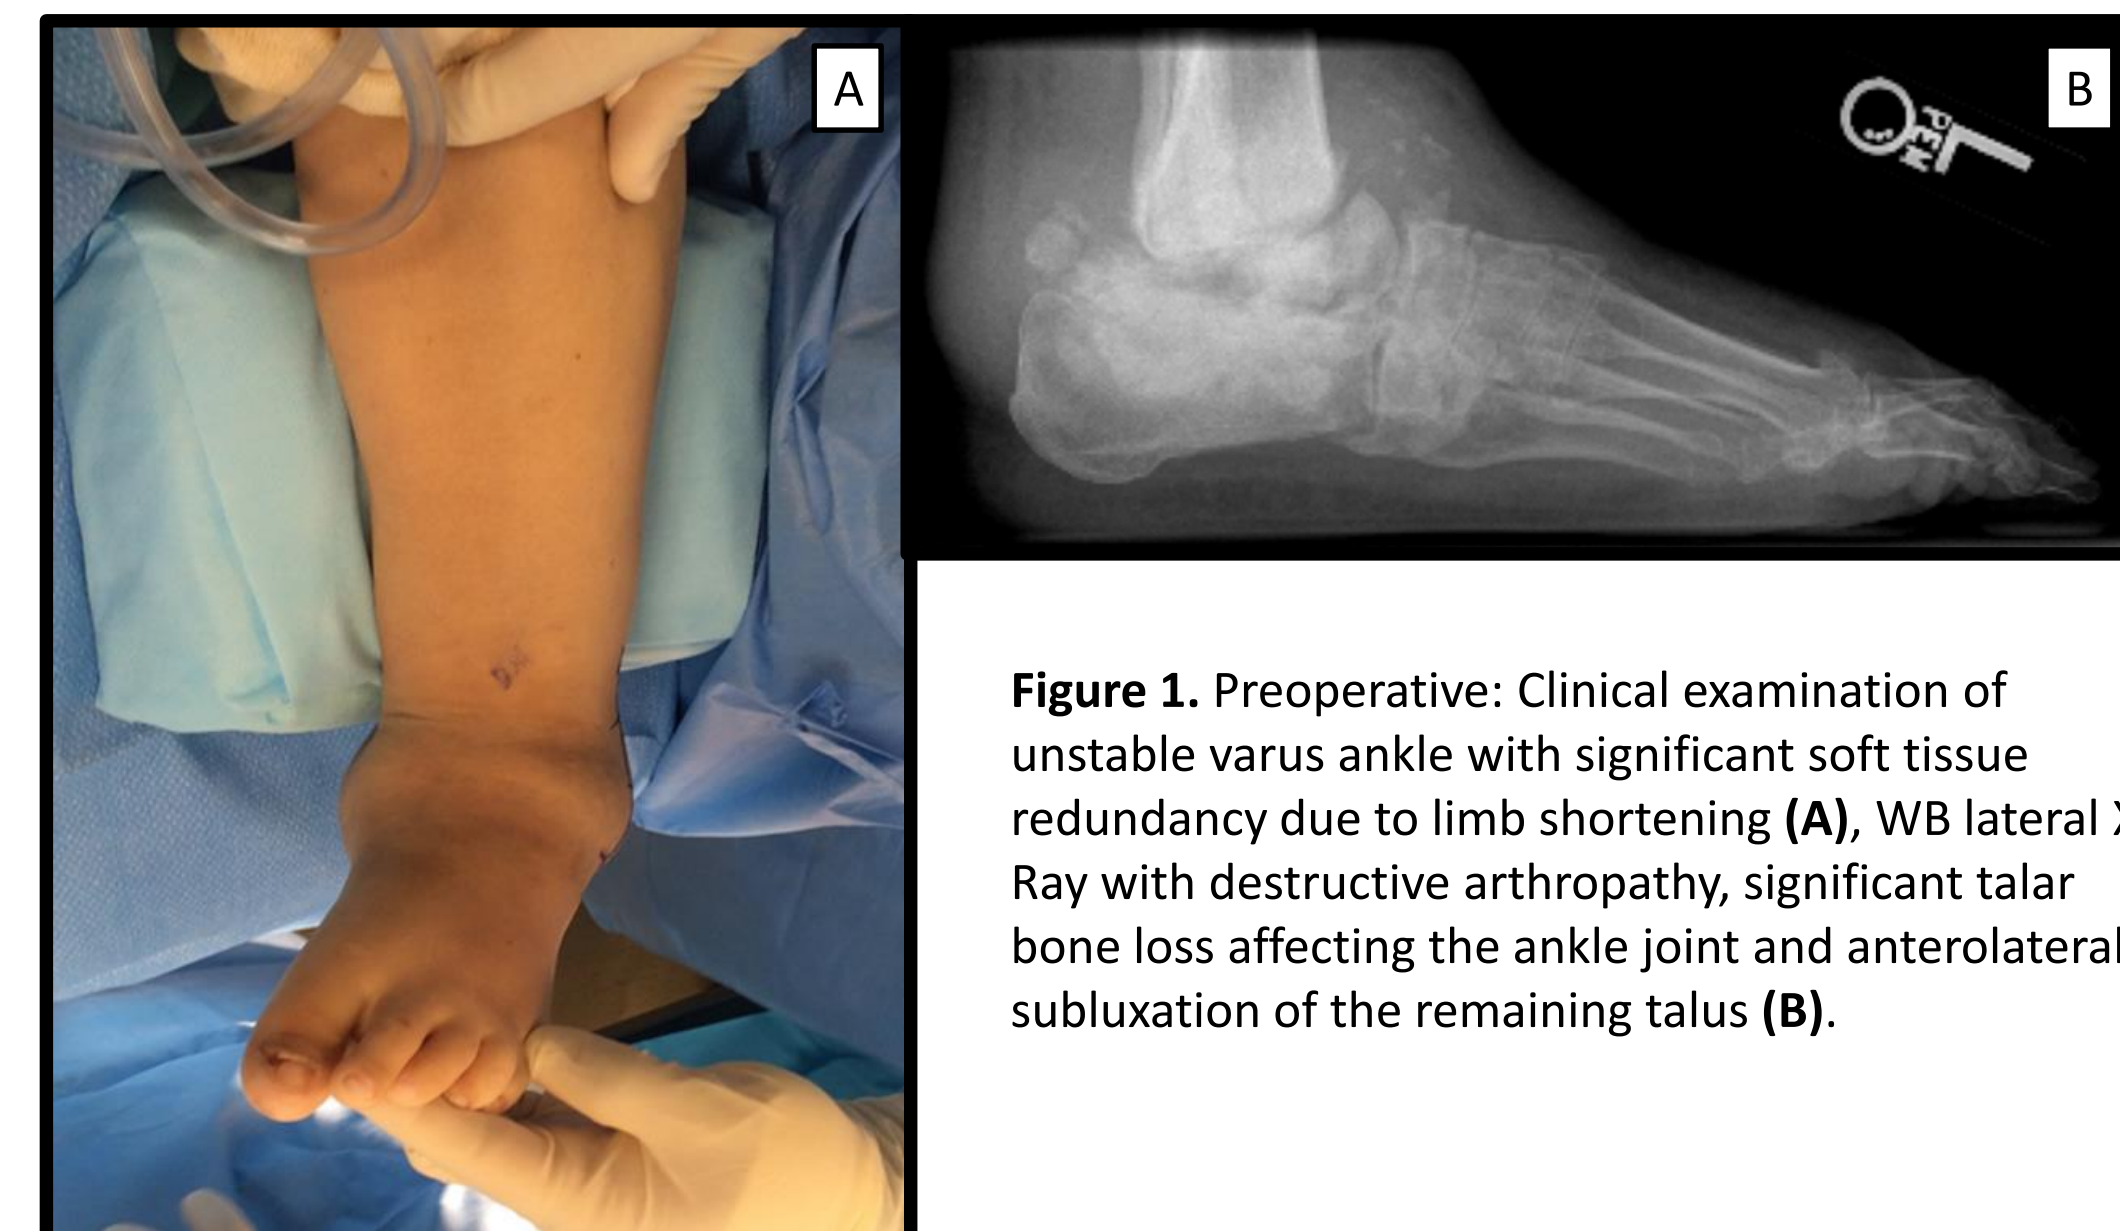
Preoperative: Clinical examination of unstable varus ankle with significant soft tissue redundancy due to limb shortening (A), WB lateral X-Ray with destructive arthropathy, significant talar bone loss affecting the ankle joint and anterolateral subluxation of the remaining talus (B).
